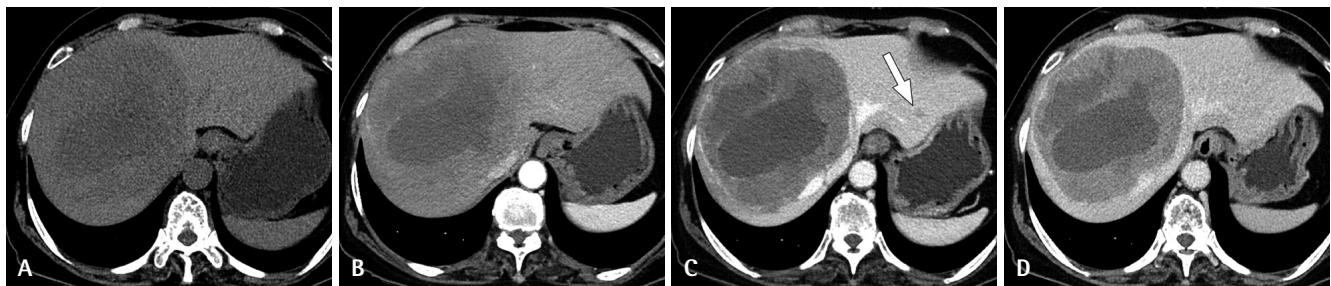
Liver dynamic computed tomography (CT) image showing two liver masses. Liver dynamic CT scan with precontrast (A), arterial (B), portal (C), and delayed (D) phases. An hepatic mass of approximately 13.5 cm in liver segments 4 and 8 showing hypoattenuation in the pre-contrast scan (A), heterogeneous enhancement in the arterial phase (B), and washout in the portal (C) and delayed (D) phases. The central area of the tumor exhibits no obvious enhancement in the portal or delayed phases, suggesting necrosis. In addition, a small hypoenhancing nodule in liver segment 2 is detected in the portal phase (C, arrow).
